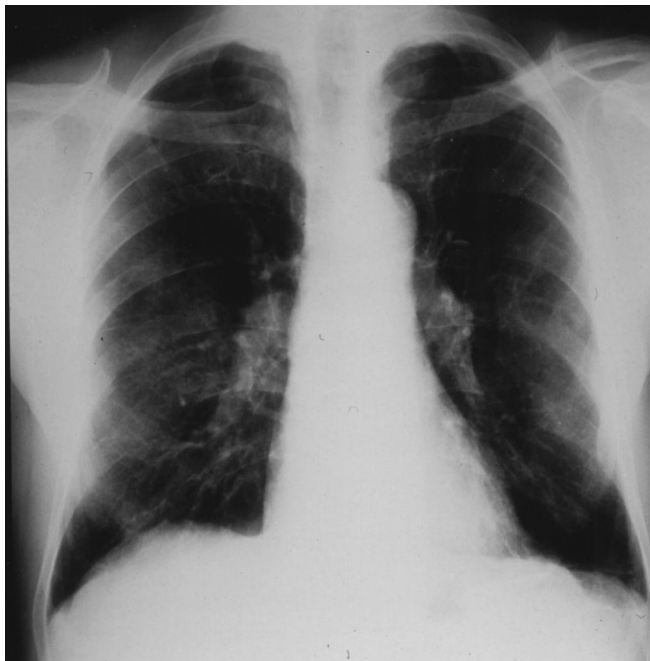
Chest X-ray of an insulator exposed to asbestos for 39 years. ILO classification: small irregular opacities t 1/0, both middle and lower lobes, adherence of the left costophrenic angle, pleural plaques 3b, right and left chest wall and diaphragm, pleural calcification 2, left and right diaphragm; Symbols inactive tuberculosis
